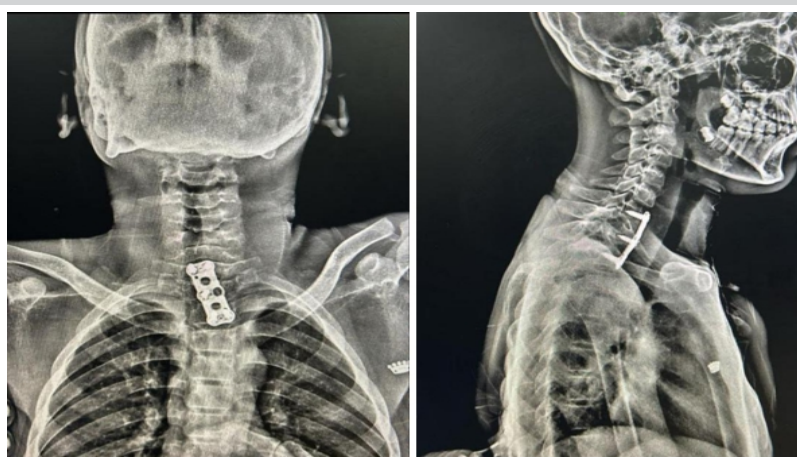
Post-operative anteroposterior and lateral cervical spine radiographs demonstrating anterior cervical plate fixation.
